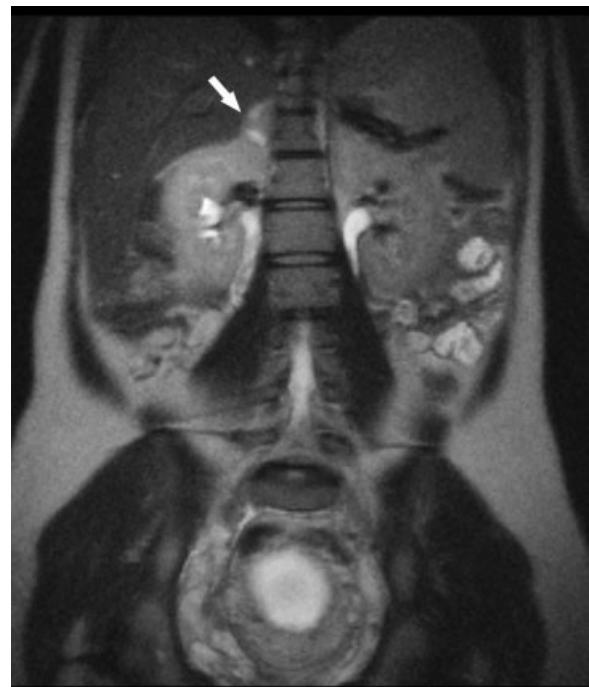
T2-weighted coronal image depicting the right adrenal gland mass (arrow). Note bilateral physiological hydronephrosis of pregnancy.
